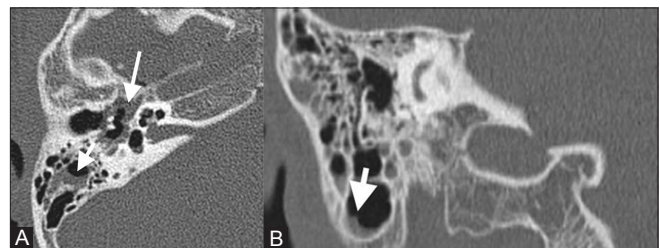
(A, B): HRCT axial and coronal images of the right temporal bone show soft tissue in the epitympanum (long arrow) and fluid level (short arrows in A and B) in the mastoid air cells. No bony erosions. The ossicles are intact - otomastoiditis
